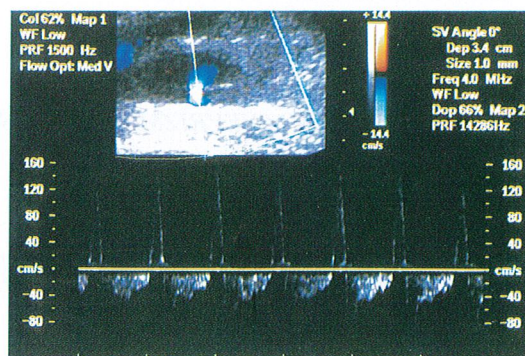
A back and forward waveform ("to and fro flow") is demonstrated in the pseudoaneurysm neck in the spectral Doppler examination.
